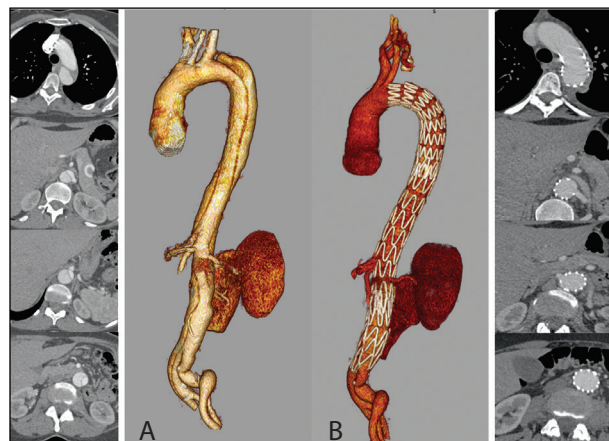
Preoperative CT scan of a subacute TBAD involving the thoracoabdominal aorta and iliac arteries (A) and post-operative result after the STABILISE procedure, showing the single unichanneled aorta and patency of visceral vessels (B).
